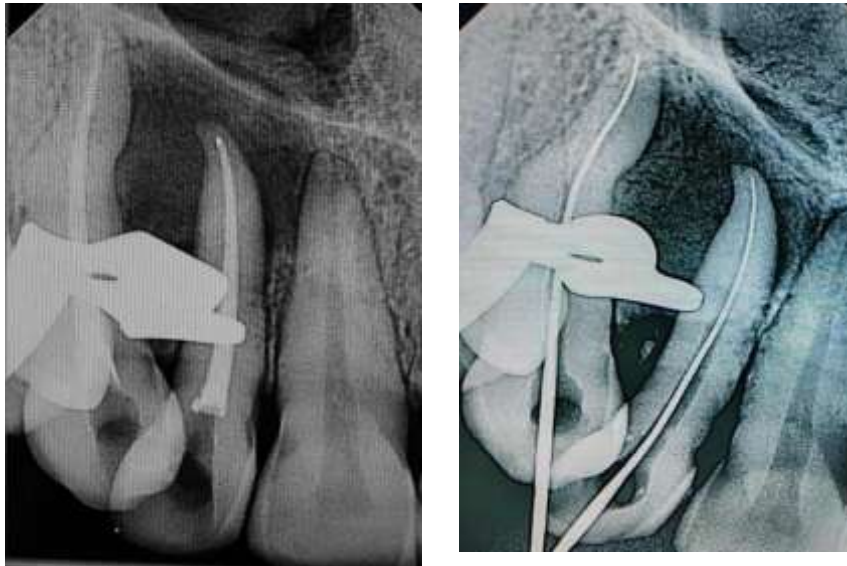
(a) Radiograph confirming Working length (b) Radiograph Showing Obturation with Single cone obturation technique in teeth 12 and 13.
